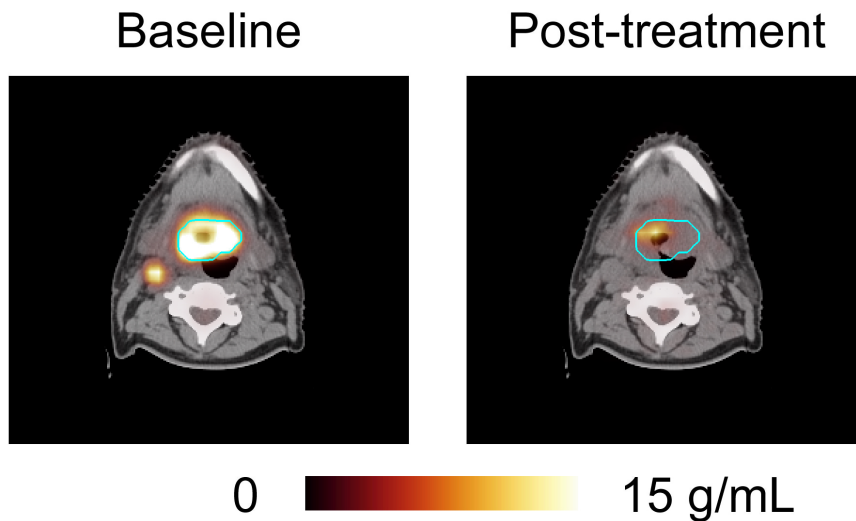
SUV changes in a single patient between baseline and post-treatment ^{18}F -FDG PET scans.
